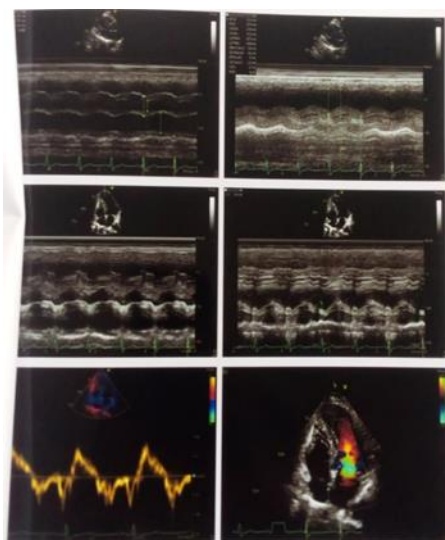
M-mode (motion mode) echocardiography of the patient.
